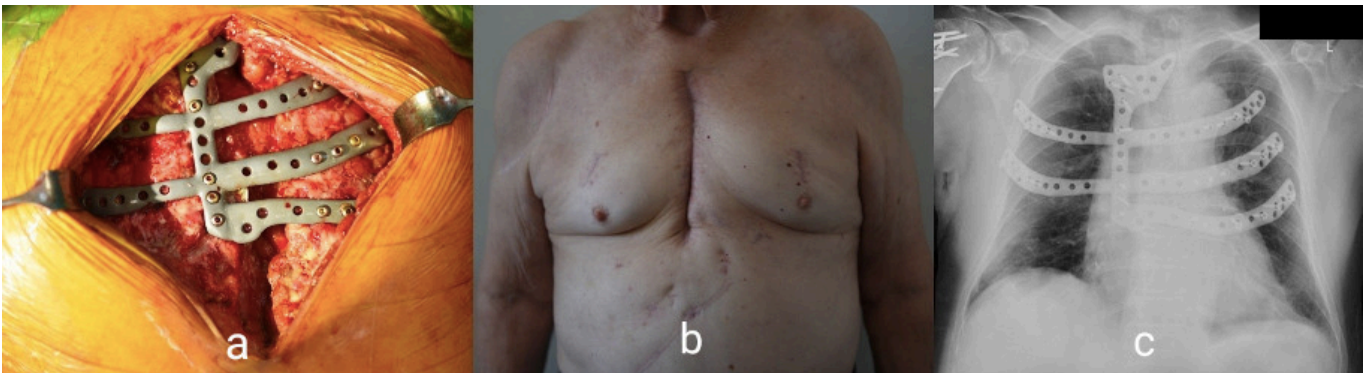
Implantation of the prosthesis and results. A) Intraoperative view; B) Final cosmetic result of the wound; C) Follow-up chest x-ray
